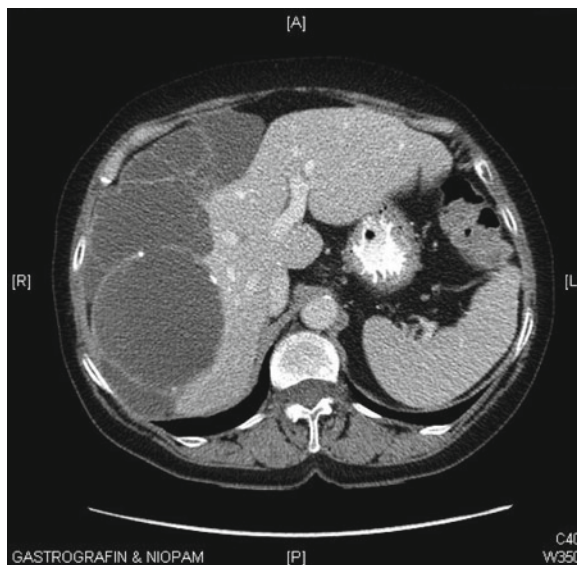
Abdominal CT showing “scalloping” of the liver
